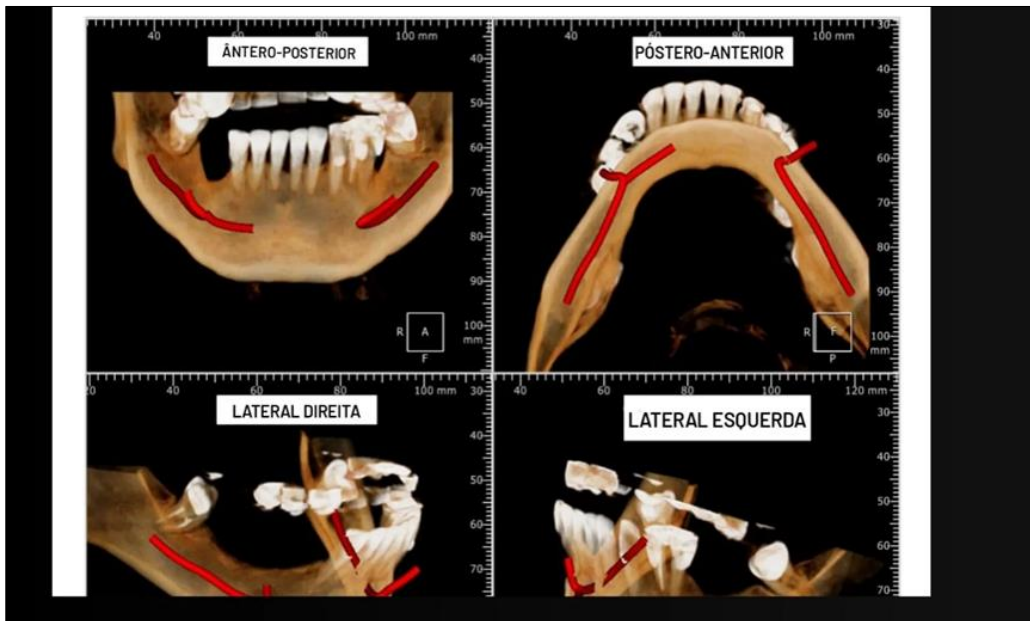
Three-dimensional reformatted of high-resolution CBCT in the mandible region²⁵
